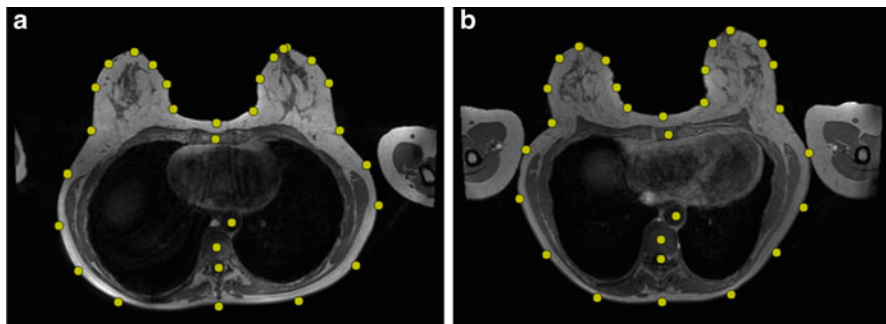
Training examples for building statistical shape models of landmarks. 2D MR images from two volunteers are overlaid with manually labelled landmarks (*yellow dots*)
